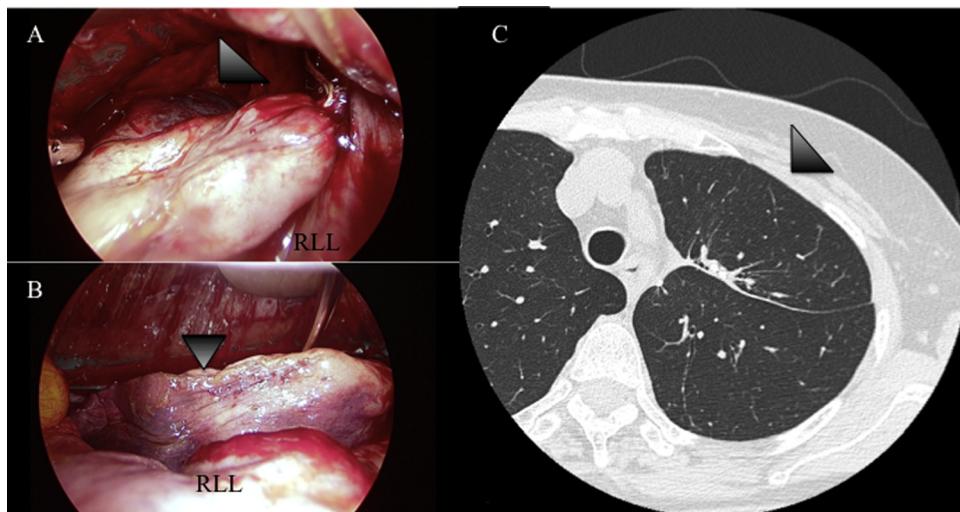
(A): Intraoperative view of the congested lingular segment, which is twisted approximately 90° clockwise (arrowhead). (B): The surface color and compliance of the lingular segment improved after detorsion. (C): Computed tomography imaging shows a sufficiently expanded lingular segment after repair. RLL: right lower lobe.
